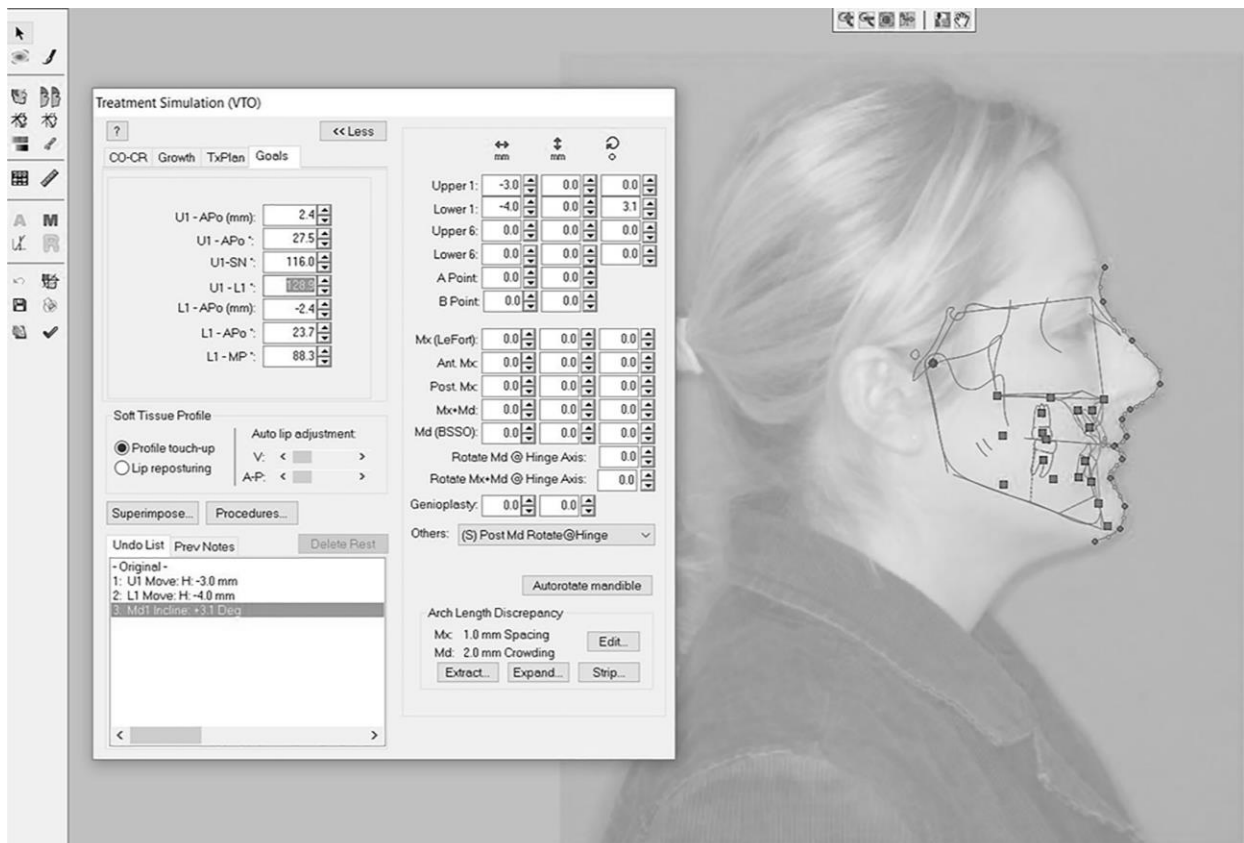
Step 1 of the prediction generation process. Superimpose the pre-treatment profile picture with digitally traced soft tissue landmarks of the pre-treatment cephalometric radiograph.
